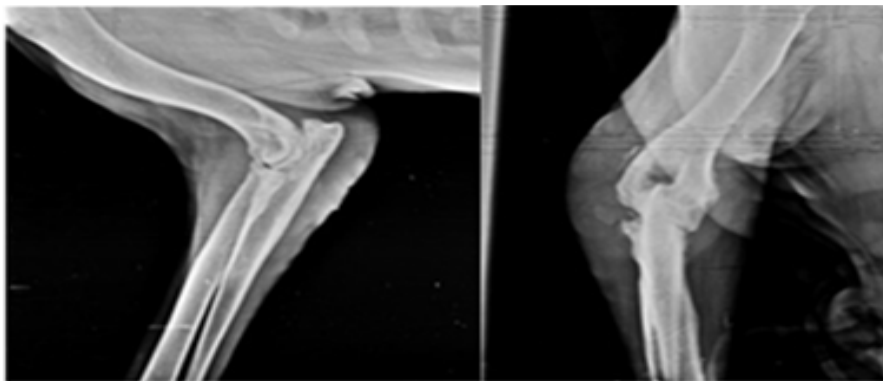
Post operative radiograph after 1 month
